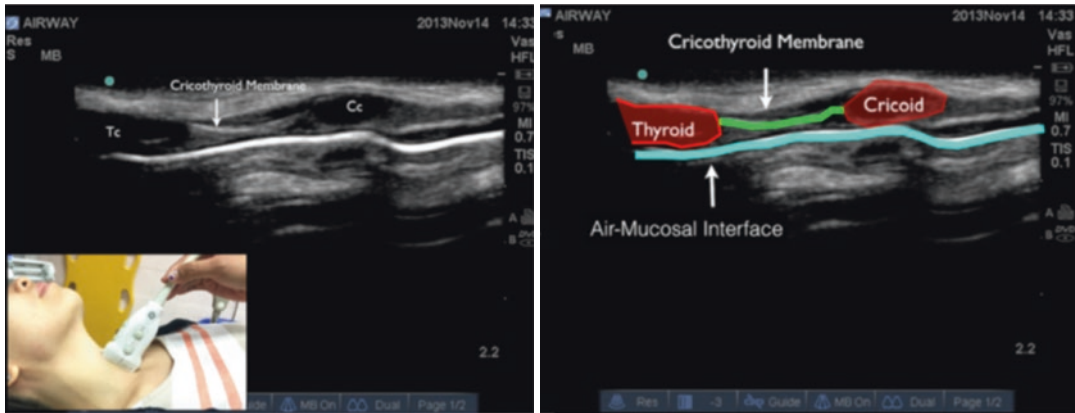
Front of neck ultrasound (from Osman and Sum [7])
